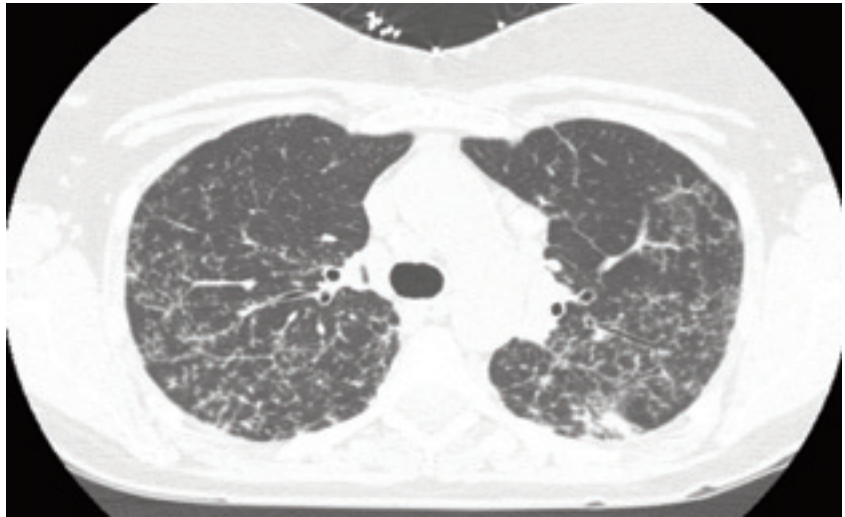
A CT image of the chest shows peribronchovascular thickening and nodularity in a patient with pulmonary sarcoidosis.
